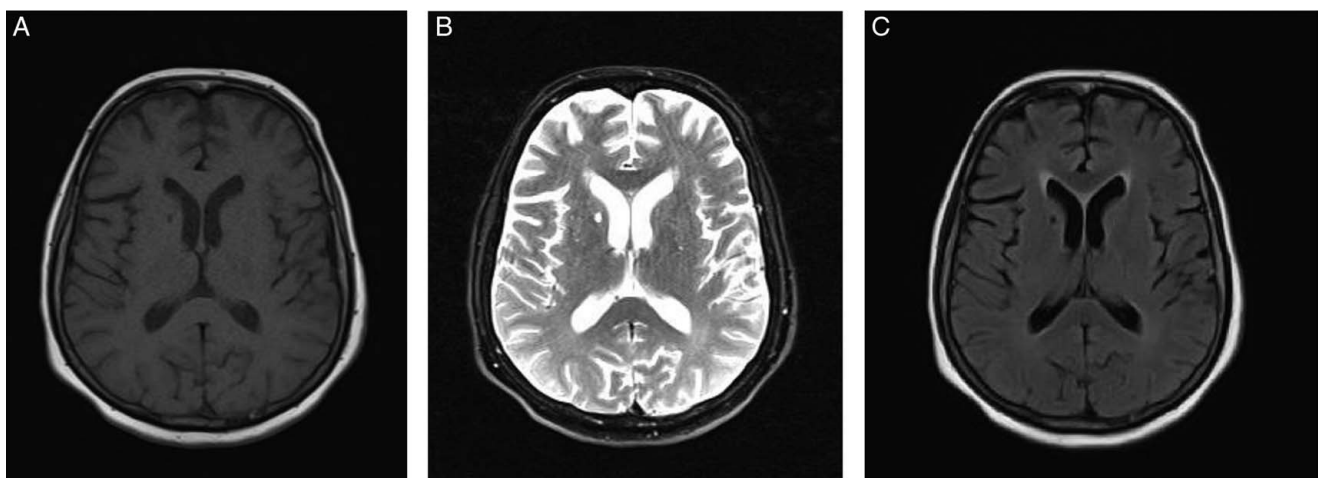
T1 (A), T2 (B) and fluid attenuated inversion recovery (FLAIR) (C) sequences of brain MRI showed no acute intracranial lesions.
